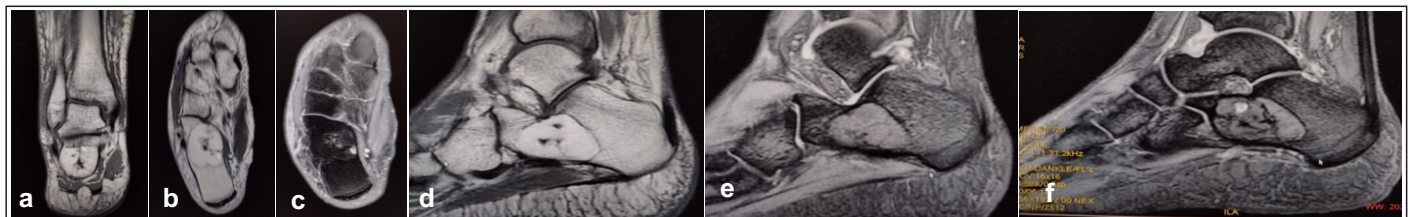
MRI of right ankle showing the intraosseous lipoma (2 a) coronal section of MRI showing the hyper intense lesion in the calcaneum, (2 b) axial section showing the hyper intense area, (2 c) STIR hypointense lesion, (2 d) sagittal section showing the hyperintense area, (2 e) calcaneum showing area of central calcification, (2 f) subtle enhancement of the lesion on post contrast study
